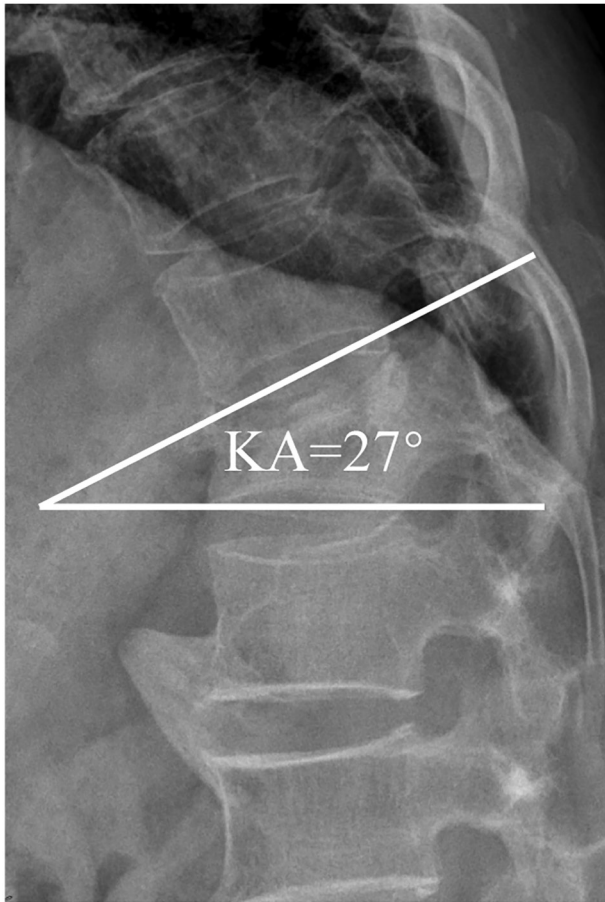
Radiographic evaluation of KA. KA was calculated from the angle of intersection of the lines parallel to the upper and lower end plates of the fractured vertebrae. KA, kyphotic angle.
